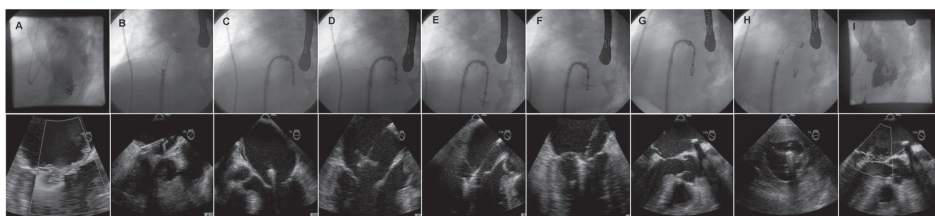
Outline of the percutaneous MV repair procedure (MitraClip) using fluoroscopic and echo guidance. Severe MR is seen by transthoracic and transesophageal echocardiography (panel A). The device sheath is placed in the left atrium after transeptal puncture (panel B). The clip is advanced just above the MV in the closed configuration (panel C). The MitraClip is then opened in the left atrium (panel D) and advanced into the left ventricle (panel E). Subsequently, the clip is pulled back in systole to stabilize the MV leaflets (panel F), the grippers are quickly lowered and the clip is closed (panel G). After confirming that the leaflets are adequately captured between an arm on the ventricular side and a gripper on the atrial side, the clip is closed in a locked position. Once a functioning double-orifice mitral valve is confirmed with echocardiography, the clip is detached (panel H). There is minimal MR after the procedure with excellent procedural outcome.
